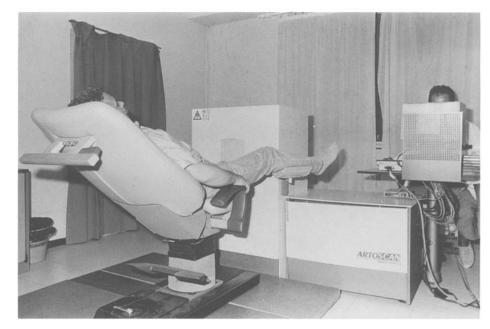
MRI dedicated unit: positioning for knee study. *MAGMA* (1994) 2(4)
